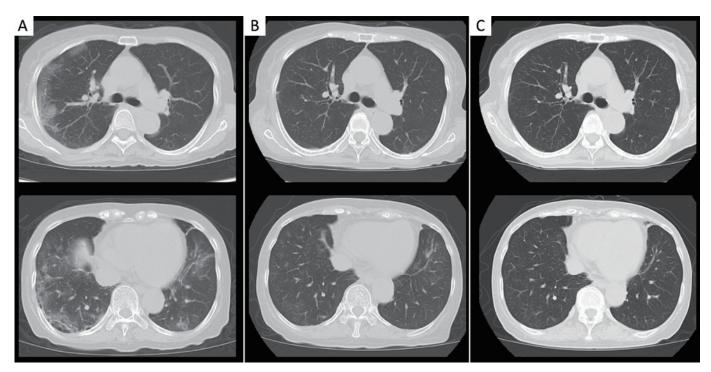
Computed tomography (CT) scans
